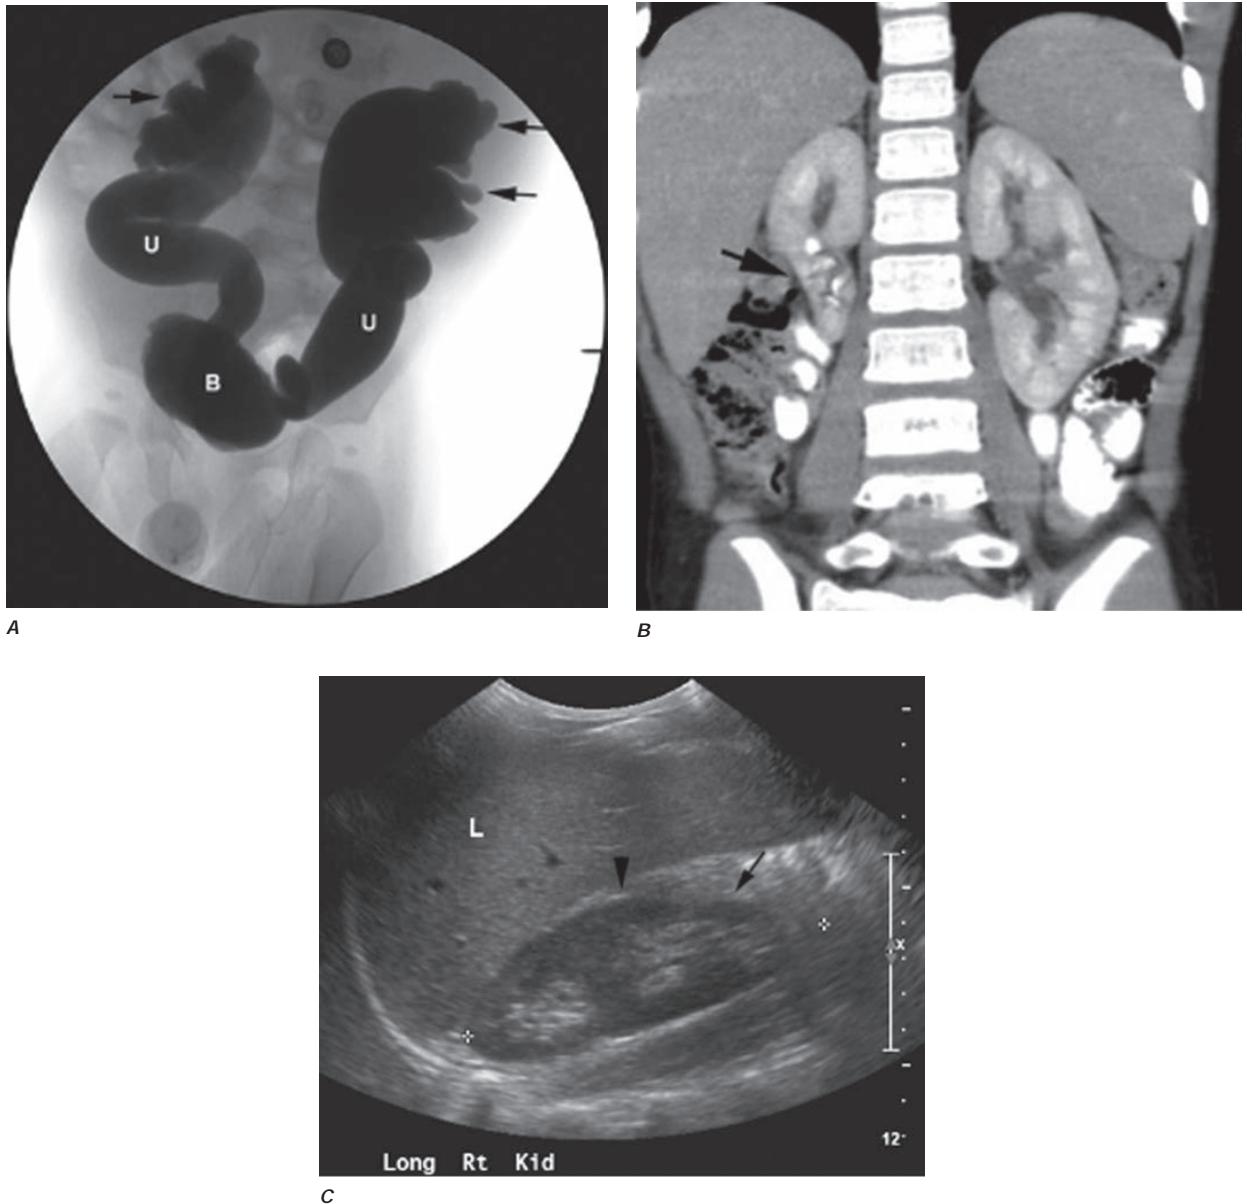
Radiographs of vesicoureteral reflux (VUR) and reflux nephropathy. *A*, Voiding cystourethrogram in a 7-month-old baby with bilateral high-grade VUR evidenced by clubbed calyces (arrows) and dilated tortuous ureters (U) entering the bladder (B). *B*, Abdominal computed tomography scan (coronal plane reconstruction) in a child showing severe scarring of the lower portion of the right kidney (arrow). *C*, Sonogram of the right kidney showing loss of parenchyma at the lower pole due to scarring (arrow) and hypertrophy of the mid-region (arrowhead). (Courtesy of Dr. George Gross, University of Maryland Medical Center; with permission.)
